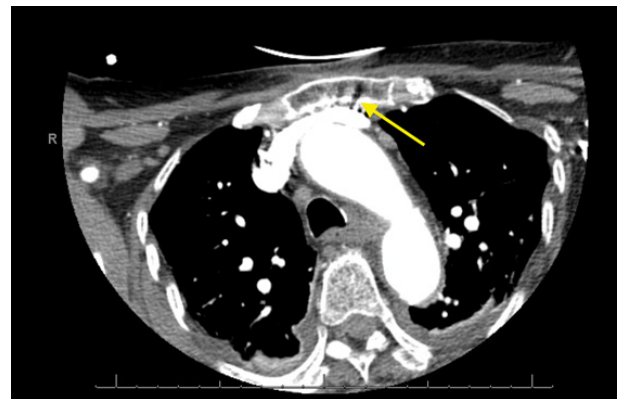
Axial CT image demonstrating a linear, undisplaced fracture of the sternal body, evident as a cortical discontinuity without displacement or associated intrathoracic injury.
